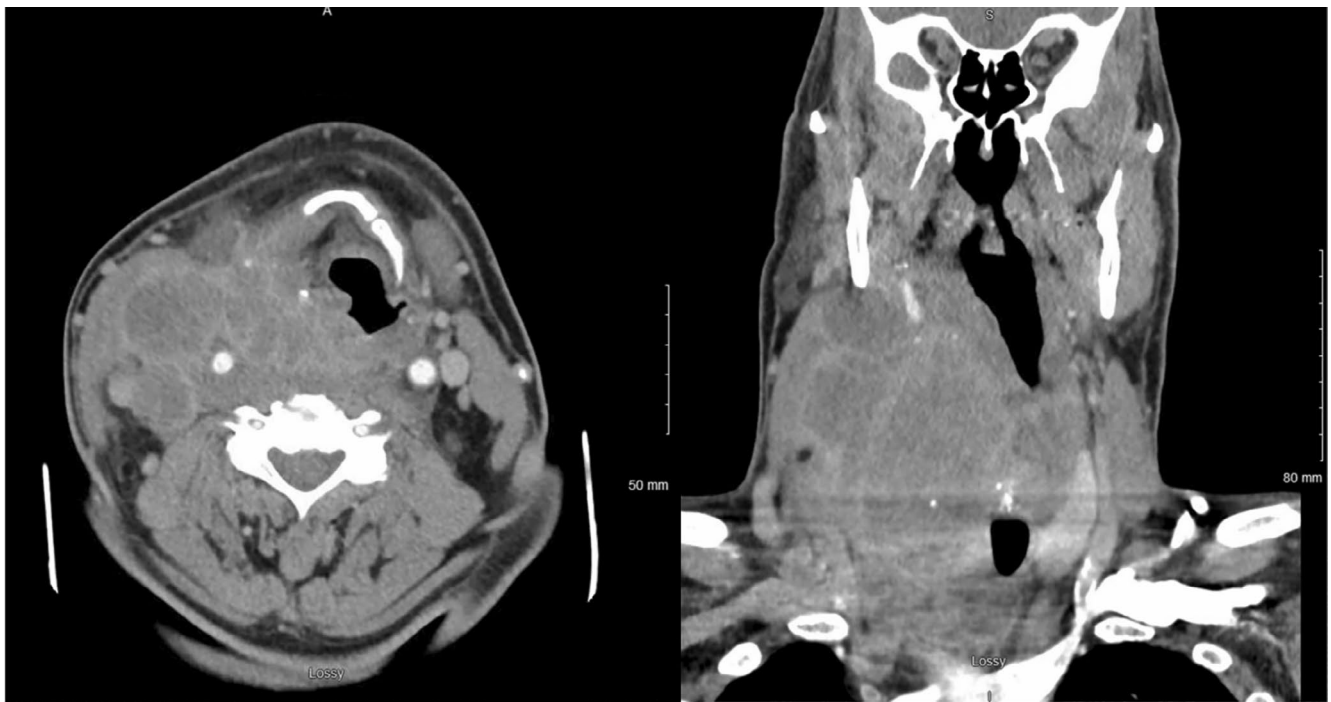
Pre-treatment contrast-enhanced CT images of the neck showing advanced locoregional disease with obliteration of the right internal jugular vein and anterolateral deviation of the aerodigestive tract.
